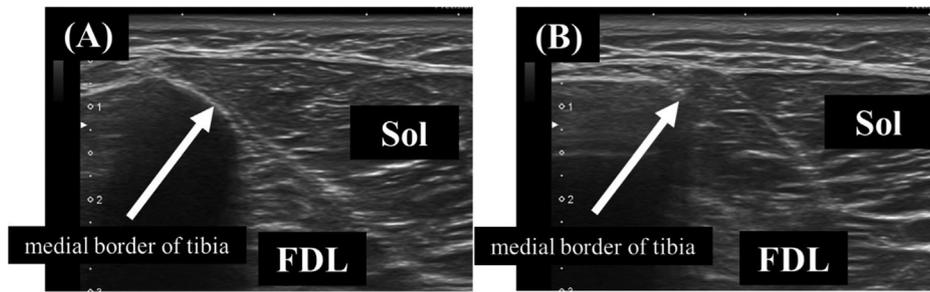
Medial tibial border on ultrasound (transverse axis). We observed whether the flexor digitorum longus (FDL) and the soleus muscle (Sol) were attached to medial border of tibia, or not, at most common location affected by medial tibial stress syndrome (MTSS). A. Representative image depicting that both the FDL and soleus were attached to the medial border of the tibia. B. Representative image depicting that the FDL was attached to the medial border of the tibia, whereas the sol was not attached to the medial border of the tibia.
